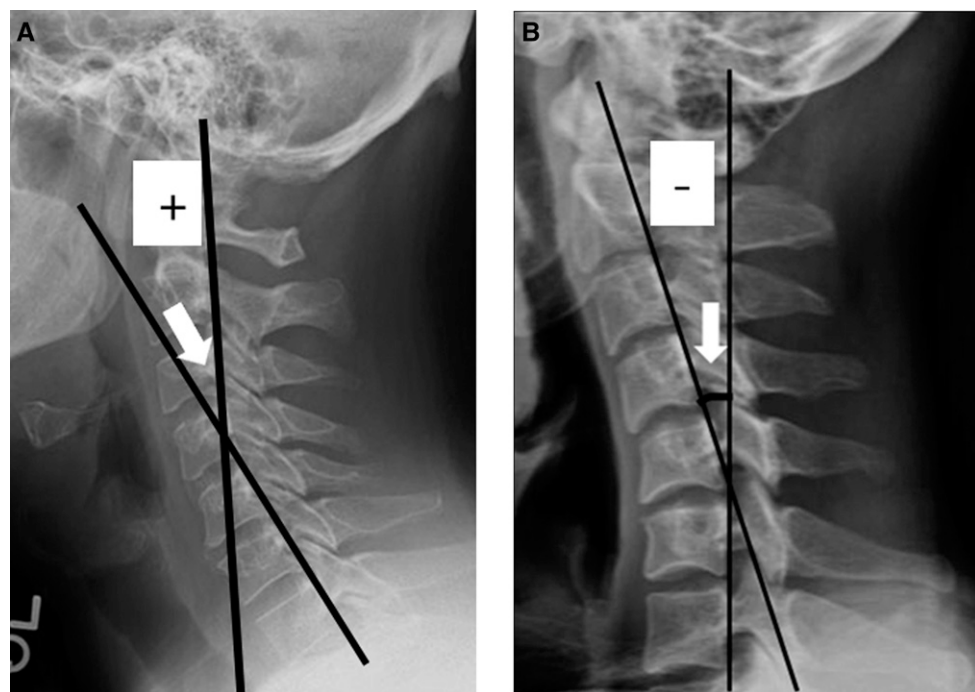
The white arrow indicates absolute rotation angle (ARA) on lateral radiographs. A.) C2-7 ARA has a positive value when the C2 line is located on the right side of the C7 line. B.) C2-7 ARA is a negative value when the C2 line is located on the left side of the C7 line.
